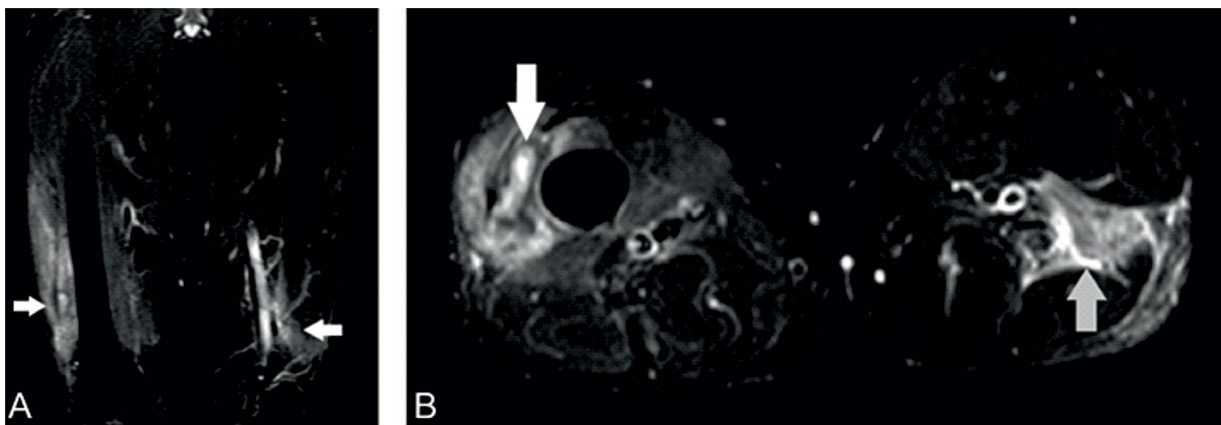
MRI of the thighs in the coronal section T2 STIR in A and axial section in B, demonstrating swelling of the right vastus lateralis and left femoral biceps muscles (white arrows in A) with collection in the right vastus medius muscle (white arrow in B), edema of the other muscles bellies with subfascial and peripheral fluid (gray arrow in B)
